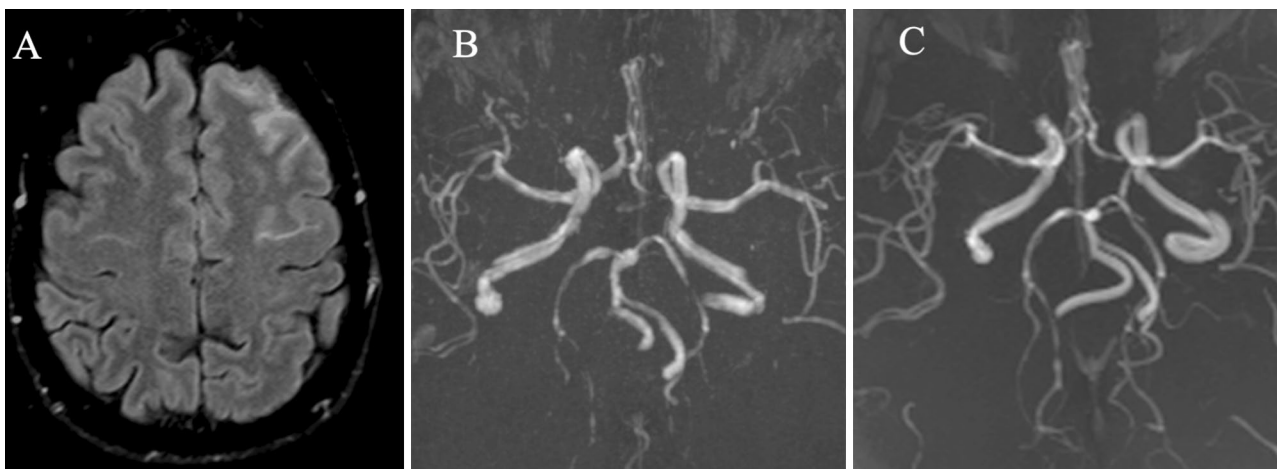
Axial fat-suppressed FLAIR (a) and coronal reformat of 3D maximum intensity projection MR Angiography (b) showing SAH in the frontal region bilaterally. There is also vasoconstriction of the arteries of the circle of Willis (b) which resolved after 3 months (c)
